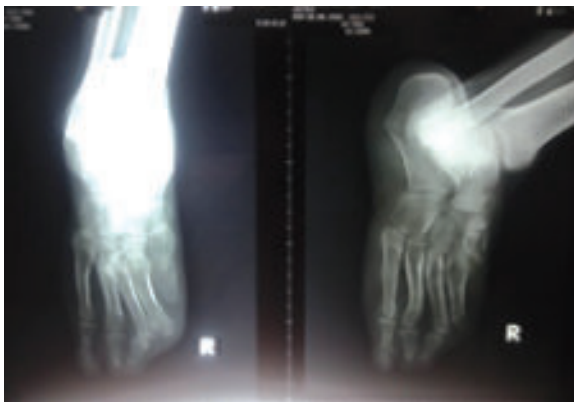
X-ray right foot
